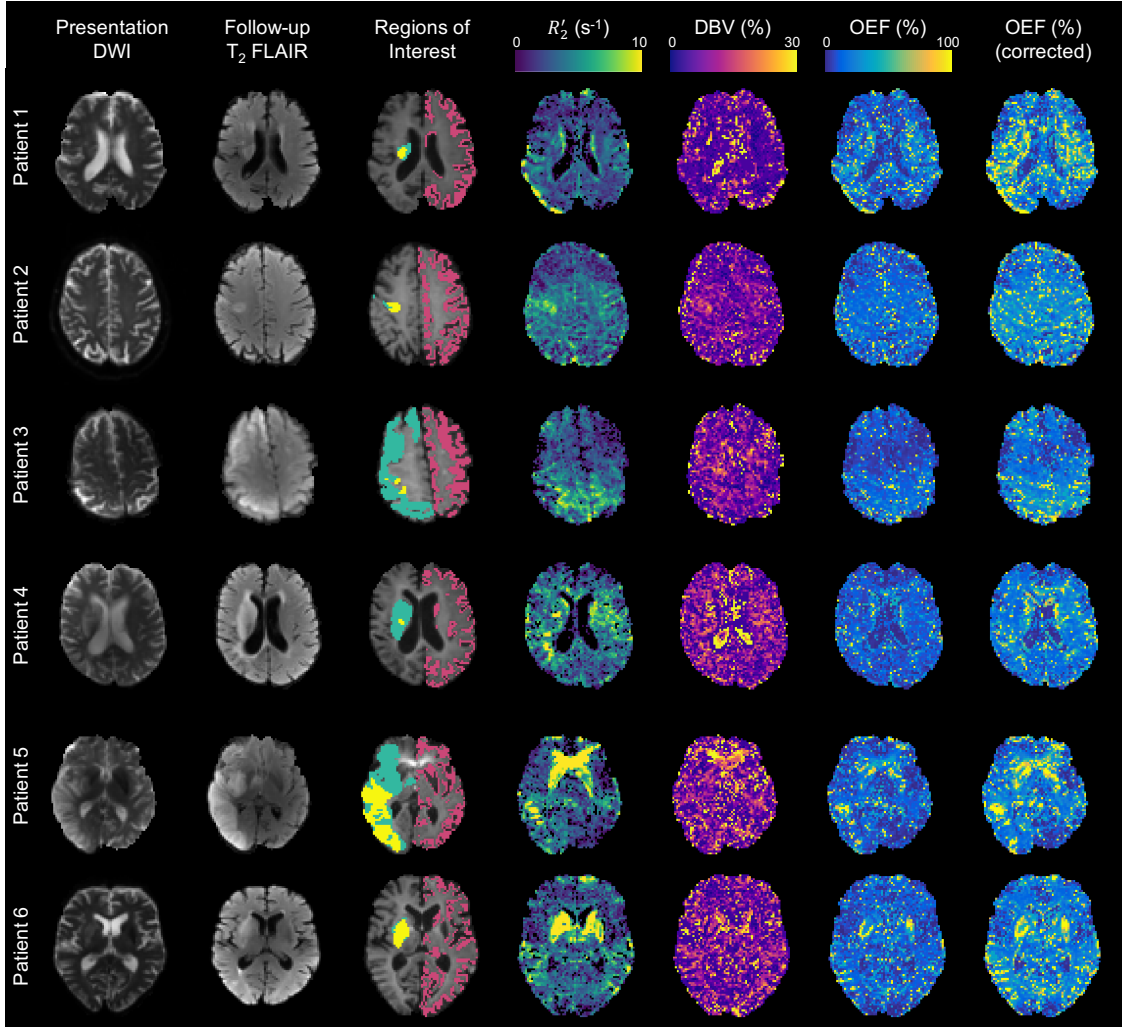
Results from six acute stroke patients (showing a single exemplary slice in each case). Columns show the presentation DWI; one week follow-up T_2 -FLAIR; three regions of interest (yellow: ischaemic core; green: infarct growth; pink: contralateral GM); estimates of R_2' , DBV, and OEF; and OEF estimated from the corrected qBOLD model.
